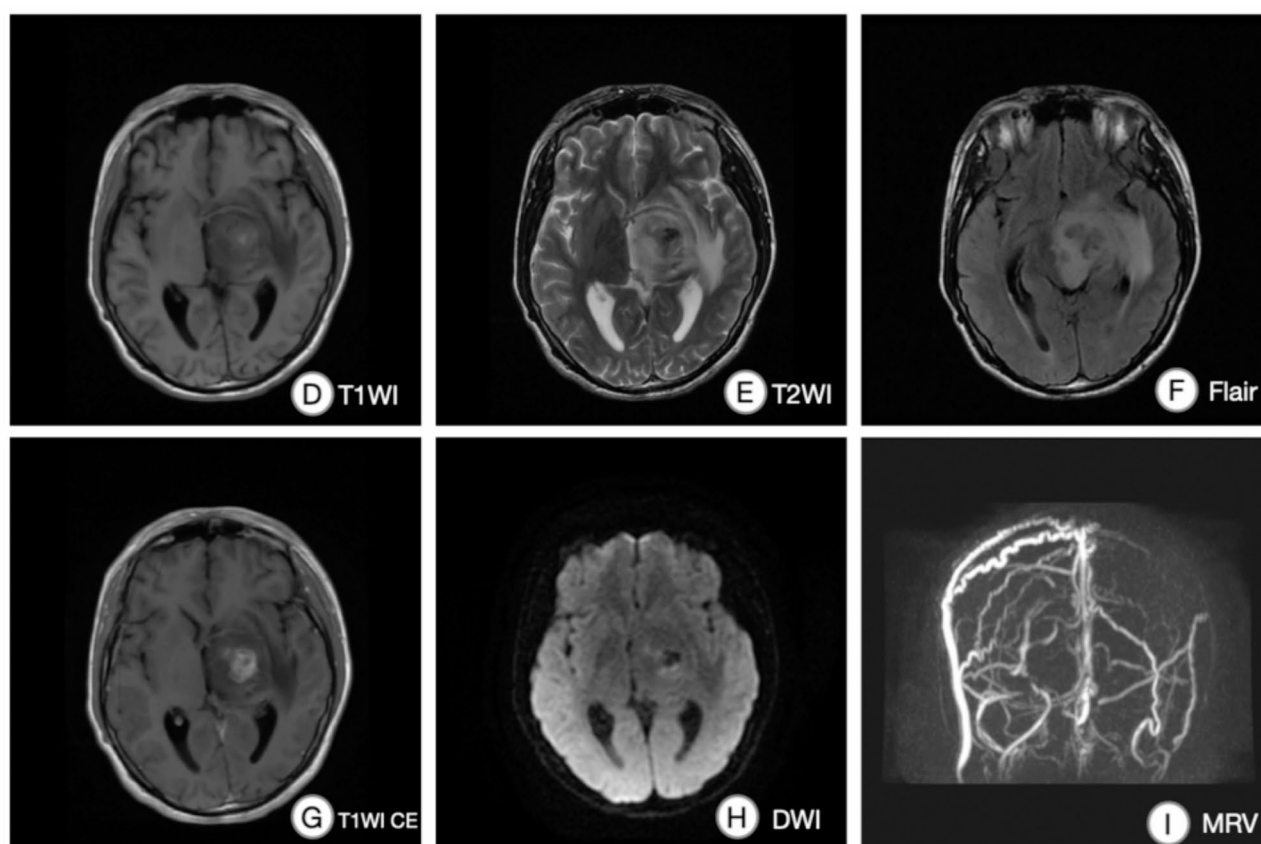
Contrast-enhanced MRI at age 18 demonstrates Patchy prolonged T1/T2 signals are observed in the left basal ganglia and thalamus. Intracerebral hemorrhage is present in the basal ganglia. (D, E). Lesions show FLAIR hyperintensity(F). Heterogeneous ring-like enhancement on post-contrast(G) Restricted diffusion on DWI(H). MRV reveals bilateral transverse and sigmoid sinus stenosis, left transverse sinusthrombosis, and dilated right cortical veins draining into the superior sagittal sinus(I)
